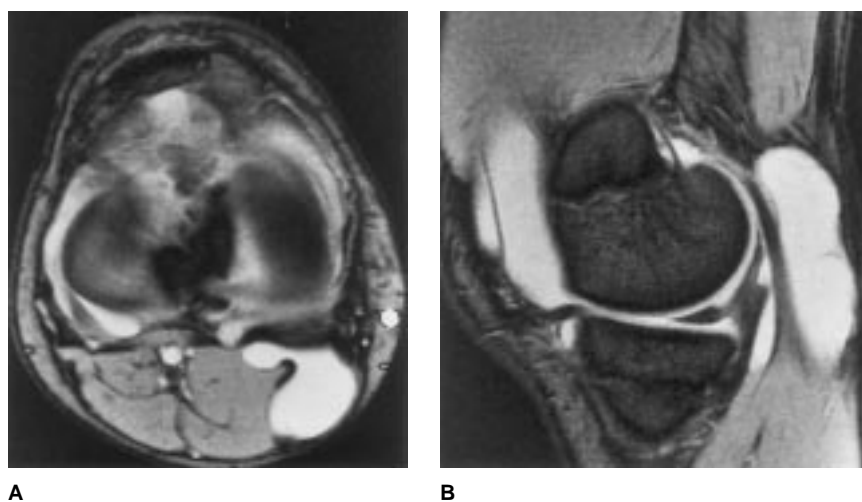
A classic Baker's cyst accompanied by intra-articular effusion as demonstrated on axial (A) and sagittal (B) T2-weighted gradient-echo MR images of the knee of a 17-year-old female basketball player. Note that the purely homogeneous fluid signal within the cyst is identical in characteristics to that of the effusion.
